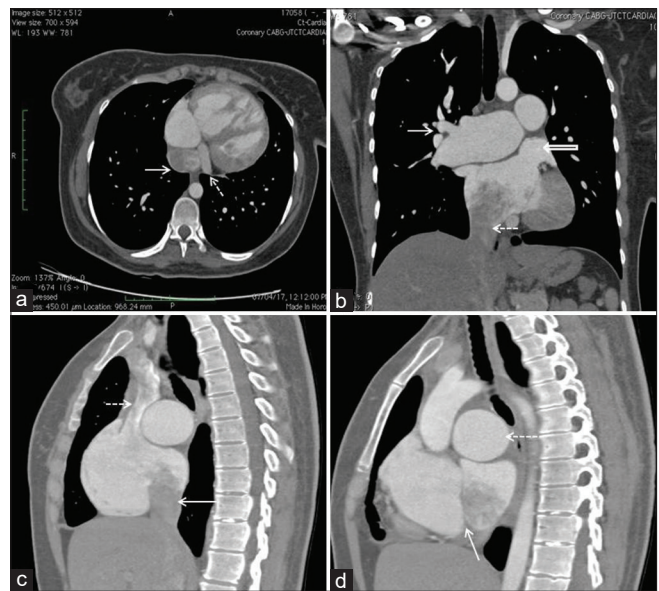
(a) Axial computed tomography section - Contrast washout in the left atrium due to anomalous inferior vena cava connection (arrow). Normal position of the coronary sinus (dotted arrow). (b) Contrast computed tomography (coronal plane) - Right middle pulmonary vein (arrow) connecting normally to the left atrium, anomalous inferior vena cava entry to left atrium (dotted arrow) and the left atrium appendage (bold arrow). (c) Contrast computed tomography (sagittal plane) - Normal drainage of right superior vena cava to right atrium (dotted arrow) and posteriorly located inferior vena cava to left atrium (arrow). (d) Contrast computed tomography (sagittal plane) - Plane of the inter atrial septum (arrow) and enlarged right pulmonary artery (dotted arrow)
